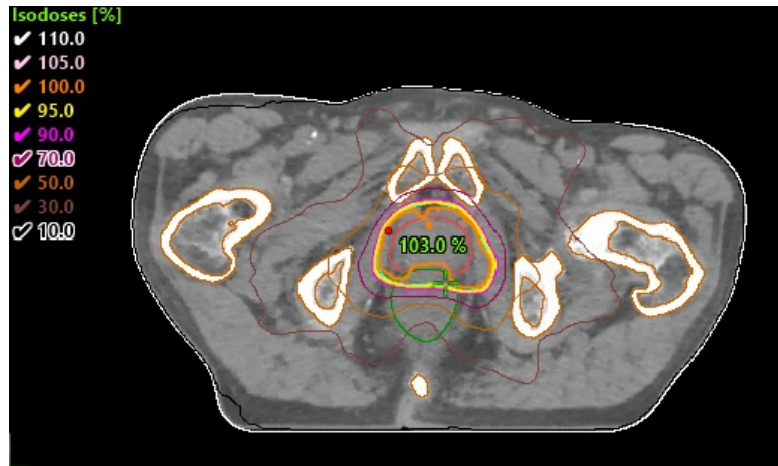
Dose distribution of patient 1 in a balanced treatment plan created in Eclipse. The figure shows the sagittal CT image of the patient and the structures of PTV (blue) and rectum (green). However, the blue line for PTV does not show on the figure since it is covered by the yellow 95%-isodose. The goal is for the 95%-isodose to cover 98% of the volume of PTV.
